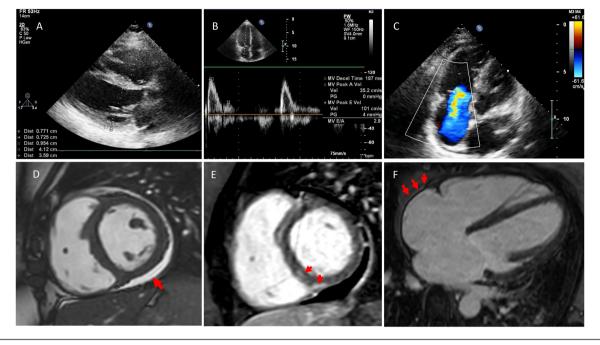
Cardiac visualization of patient. (A–C) Echocardiograms. (A) Enlangered right ventricle and normal size of left ventricle; (B) restrictive dysfunction of left ventricle; (C) sever tricuspid regurgitation by Doppler. (D–F) Cardiac MRI with gadolinium. (D) Short axis view at mid-level, arrows show fluid in the pericardial cavity, E - short axis view, foci of late gadolinium enhancement along posterior wall of LV and posterior septal segment, F - four-chamber view, areas of late gadolinium enhancement along the right atrium myocardium.
